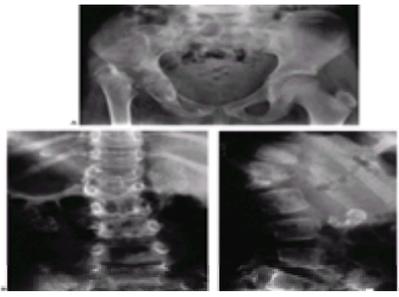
A: Anteroposterior (AP) radiograph of a 10-year-old girl from Mexico who had a past history of several operations on the right hip for tuberculosis presented with increasing back pain and kyphosis. B and C: AP and lateral views of the spine show bony destruction of the vertebral body, with relative preservation of the intervertebral disc and the calcified node; both are features of tuberculosis. Open biopsy confirmed the diagnosis of tuberculosis. (Courtesy of Hugh Watts, M.D.)
